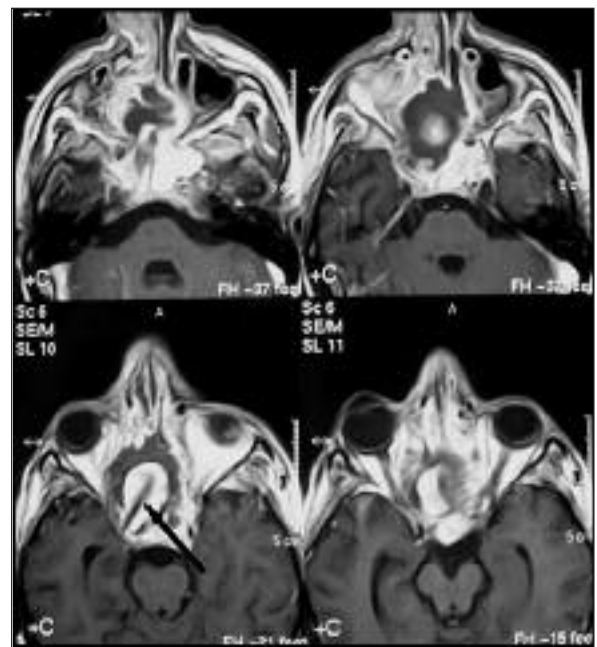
Contrast enhanced axial T1 weighted MRI shows hypointense peripheral thrombi and jet flow (arrow) within the enhancing aneurysm.
